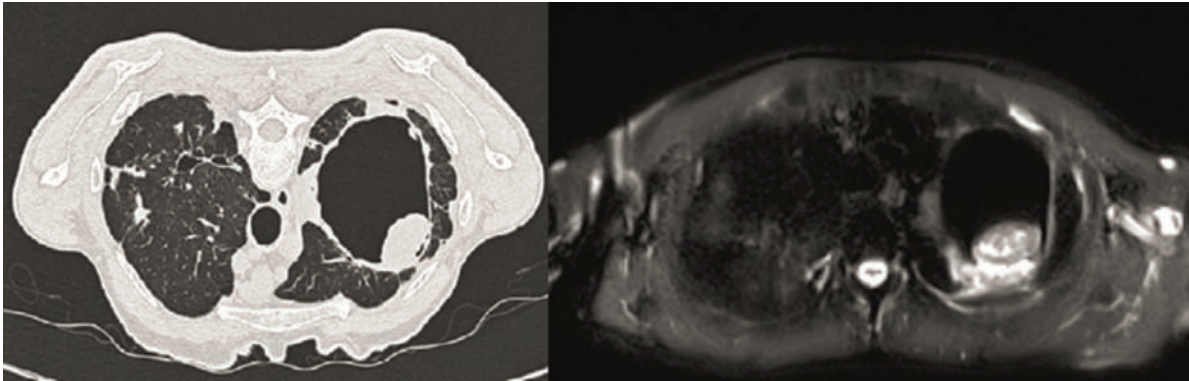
Axial CT image (lung window) in prone position (left) & axial fat-suppressed T2W MRI image (right) showing fungal ball in cavitary lesion of left upper lobe
